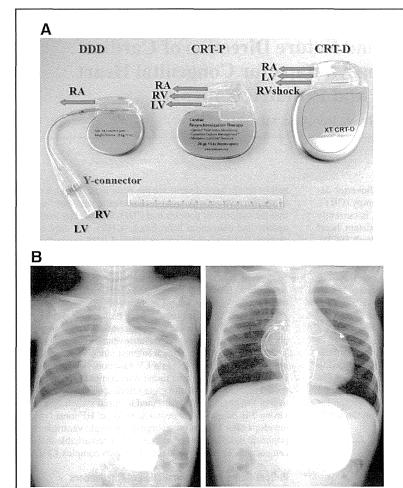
(A) Examples of conventional DDD, CRT with a biventricular pacemaker (CRT-P), and CRT with a defibrillator (CRT-D) for size comparison. The DDD device (Left) is smaller than the others but a Y-connector is necessary for simultaneous biventricular pacing, which occupies considerable subcutaneous space. Interventricular delay cannot be set in the DDD device, compared with the CRT-P (Middle) and CRT-D devices (Right), although the last one is much larger than the others. (B) Chest X-ray films of a 16-month-old patient, weighing 6.7kg, with autoantibody-associated congenital complete heart block. Severe heart failure developed 11 months after implantation of right ventricular single-site pace-maker (Left). The child was transferred to Tsukuba University Hospital with intratracheal intubation, because the hospital admitting the patient did not meet the institutional criteria for CRT-P use. Heart failure resolved completely 8 months after pacemaker upgrade to CRT-P (Right). Cardiothoracic ratio decreased from 70 to 55%, and QRS duration shortened from 150 to 120 ms. Serum BNP fell from 6,520 before CRT to 28 pg/ml after CRT.
